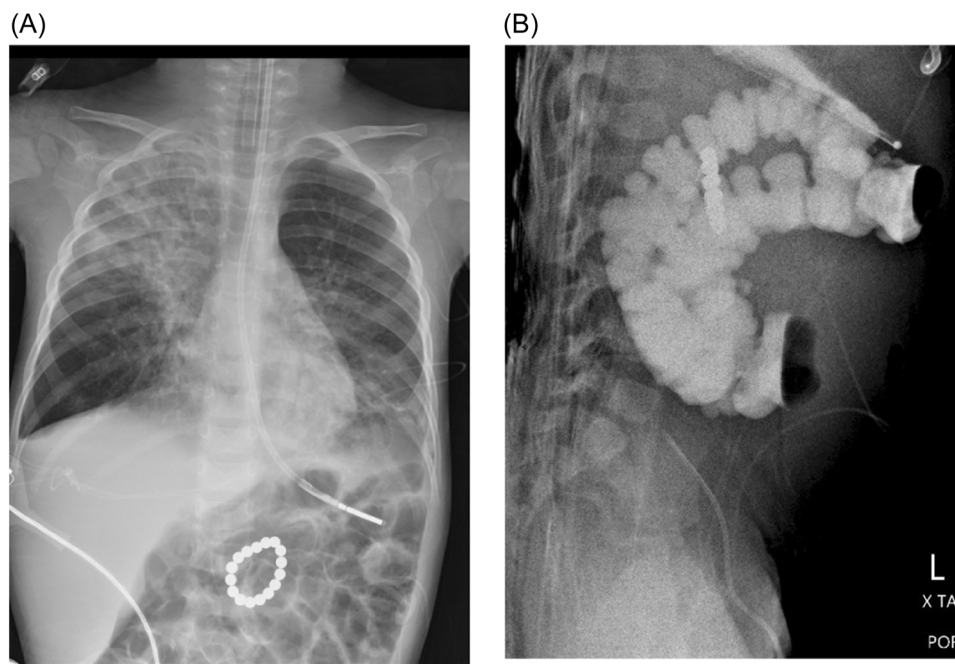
X-Ray images: (A) chest and abdomen- anteroposterior view. (B) abdomen- lateral view with enteral contrast.
